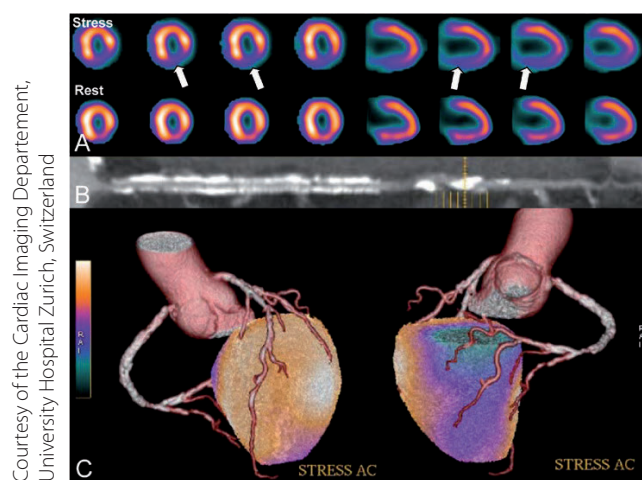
Hybrid three-dimensional volume-rendered PET/CT images in an 80-year-old gentleman. The stress and rest perfusion images (A) document inferior ischaemia. His CT coronary angiogram (B) reveals intracoronary stents encompassing the whole right coronary artery. Hybrid imaging (C) shows superposition of the right coronary artery and the inferior perfusion defect, raising the strong suspicion of in-stent restenosis of the right coronary artery
